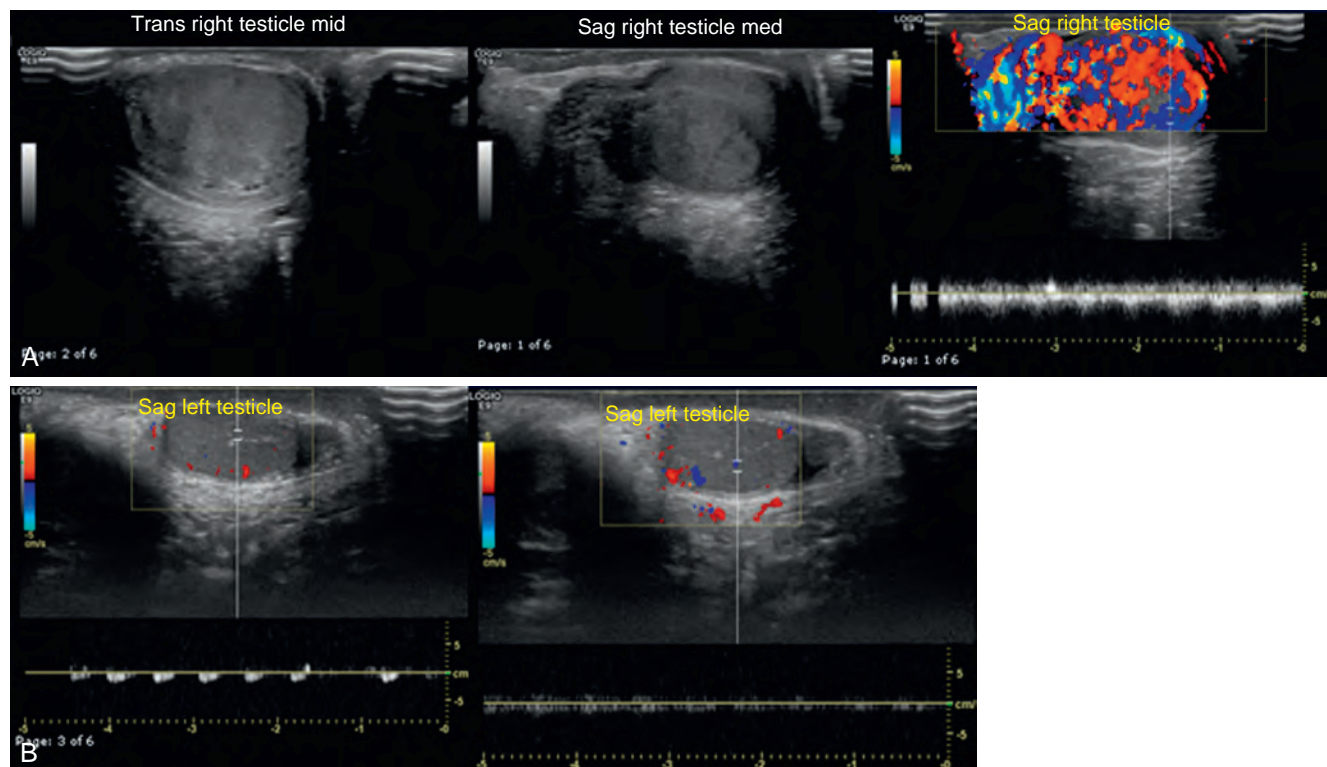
Scrotal sonogram in a 2-year-old boy for an enlarged right testis (A), ultimately found to be a yolk sac tumor. For comparison, the normal left testis (B) is shown.
